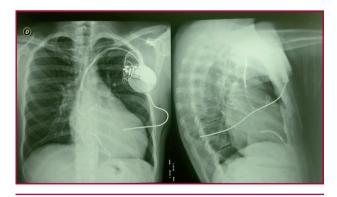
Posteroanterior and lateral chest x-ray. The subcutaneous defibrillator catheter is tunneled posterior to the heart (SQ 6996, Medtronic, Minneapolis,MN).
